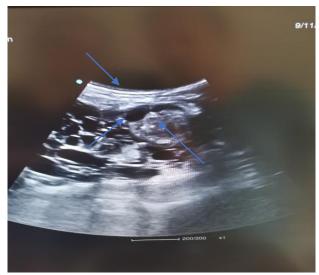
Ultrasound imaging reveals a cystic formation containing echogenic material
